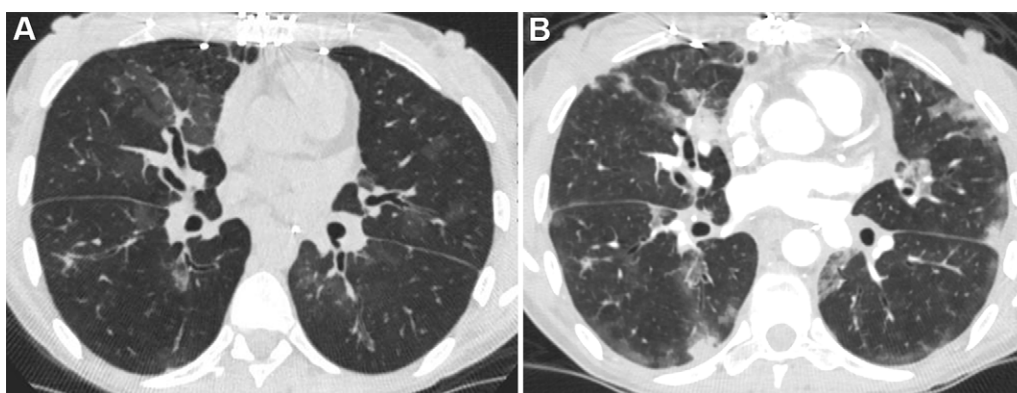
Images in a 35-year-old man with acute cellular rejection after bilateral lung transplantation for cystic fibrosis. (A) Axial chest CT lung window image 2 years and 7 months after transplantation shows bilateral ground-glass opacities. (B) Axial chest CT lung window image 2 years and 8 months after transplantation shows increased mixed-attenuation nodular opacities.
